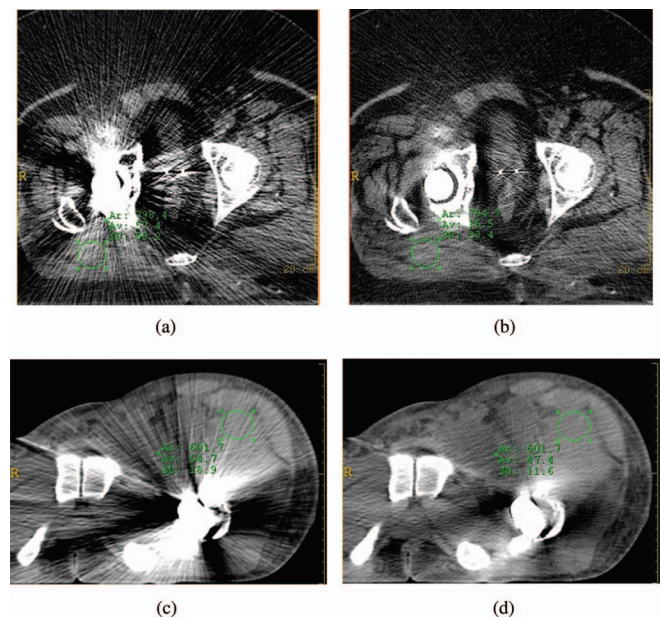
Improvement of CT Hounsfield number accuracy and noise on two patient cases with unilateral hip implants after metal artifact reduction. The image display window width is 400 HU, and window level is 800 HU. (a) Before O-MAR correction ROI CT number = 57.4 HU, $\sigma = 50.2$ HU. (b) After O-MAR correction ROI CT number = 35.5 HU, $\sigma = 33.4$ HU. (c) Before O-MAR correction ROI CT number = 64.7 HU, $\sigma = 18.9$ HU. (d) After O-MAR correction ROI CT number = 47.4 HU, $\sigma = 11.6$ HU.
